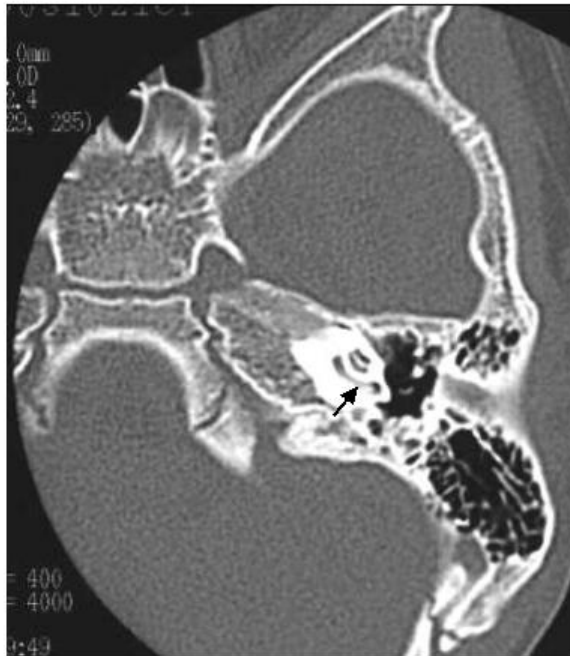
An axial HRCT from case 2 shows opacity of the lumen of the left cochlea.
